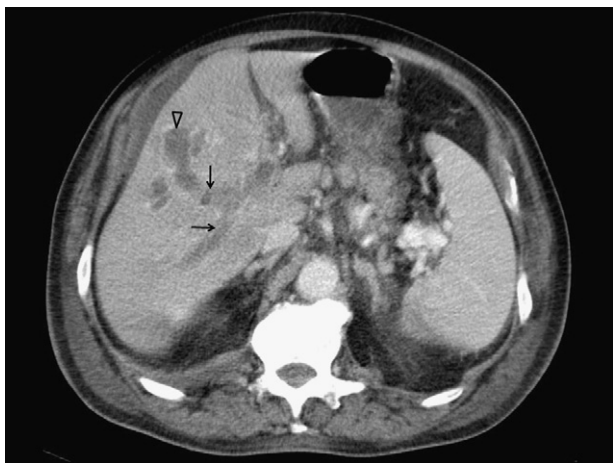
Repeat CT scan in portal phase showing complete nonenhancing filling defect within the lumen of right anterior and posterior portal veins (arrows). Note an abscess communicating with the thrombosed right anterior portal vein (arrowhead).
